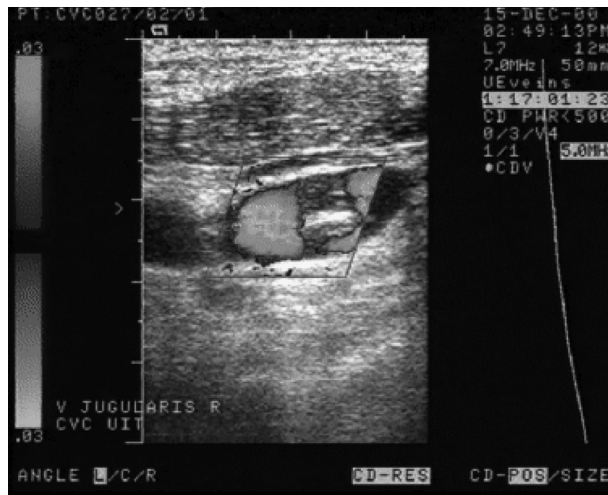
Nearly occlusive mural thrombosis visualized by a flow defect, detected by Doppler Flow Imaging, just after central venous catheter removal.
